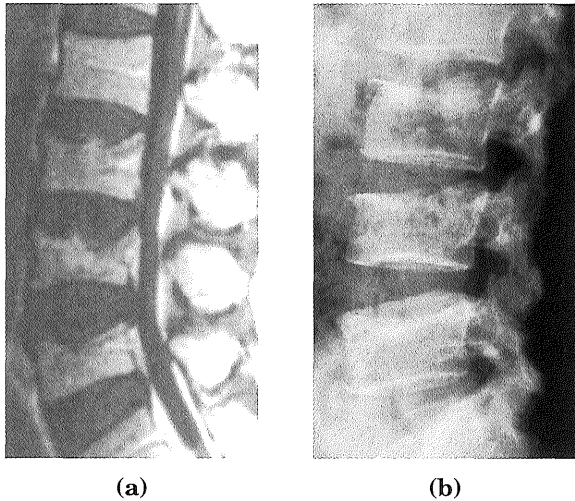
MRI (a) and lumbar X-ray (b) showed osteolytic findings of the 2nd, 3rd, and 4th lumbar vertebrae 6 months after hepatectomy.
